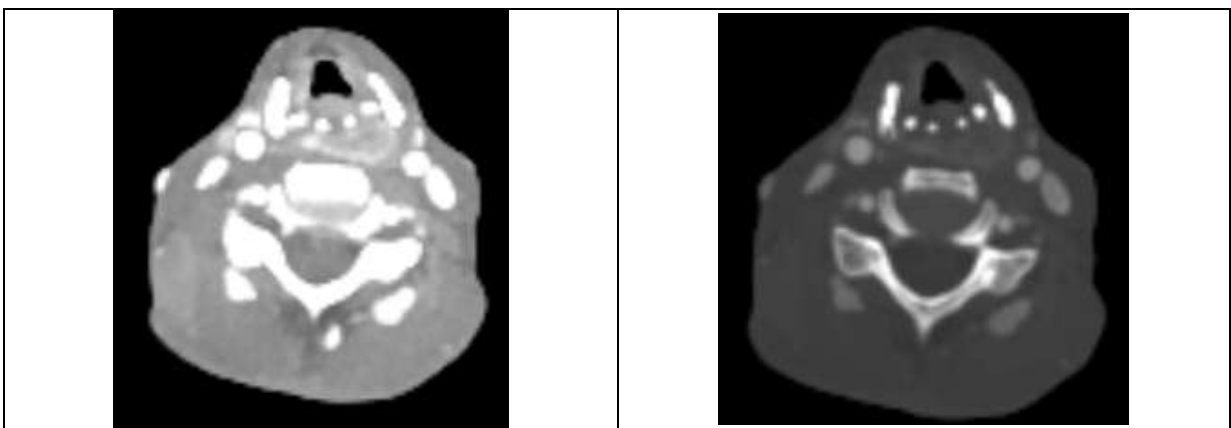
(a) and 11(b): Axial CECT and CT bone images at the level of arytenoid cartilage in a case of Ca hypopharynx shows sclerosis of bilateral arytenoid cartilages and thyroid cartilages
